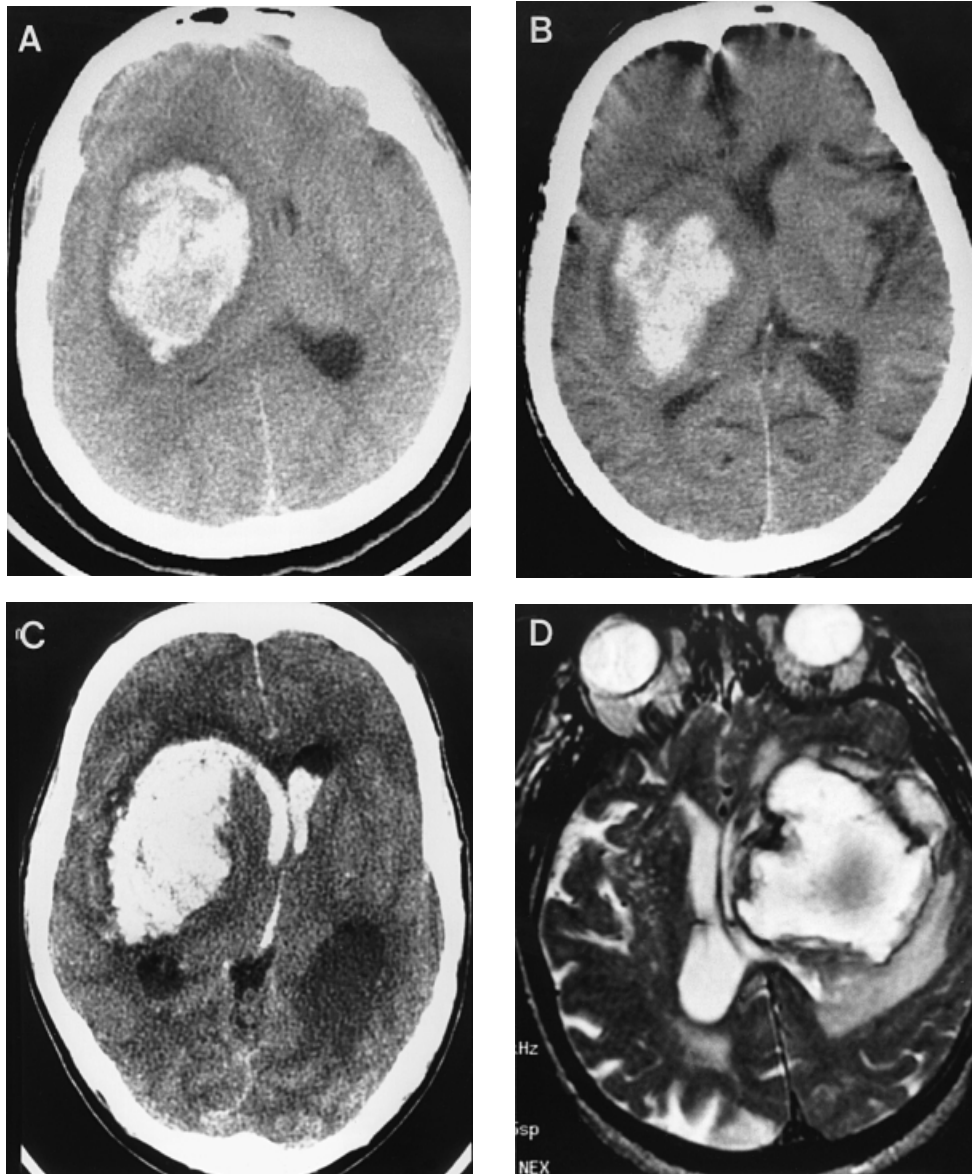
CT (A–C) and MR (D) images showing the massive type of SCH. Haematomas are huge and occupy the entire striatocapsular area but occasionally save the caudate nucleus and anterior limb of the internal capsule (C). They often rupture into the anterior horn of the lateral ventricle through its most lateral portion and often compress or extend medially into the lateral portion of the putamen (A–D). Each picture is from a different patient.
